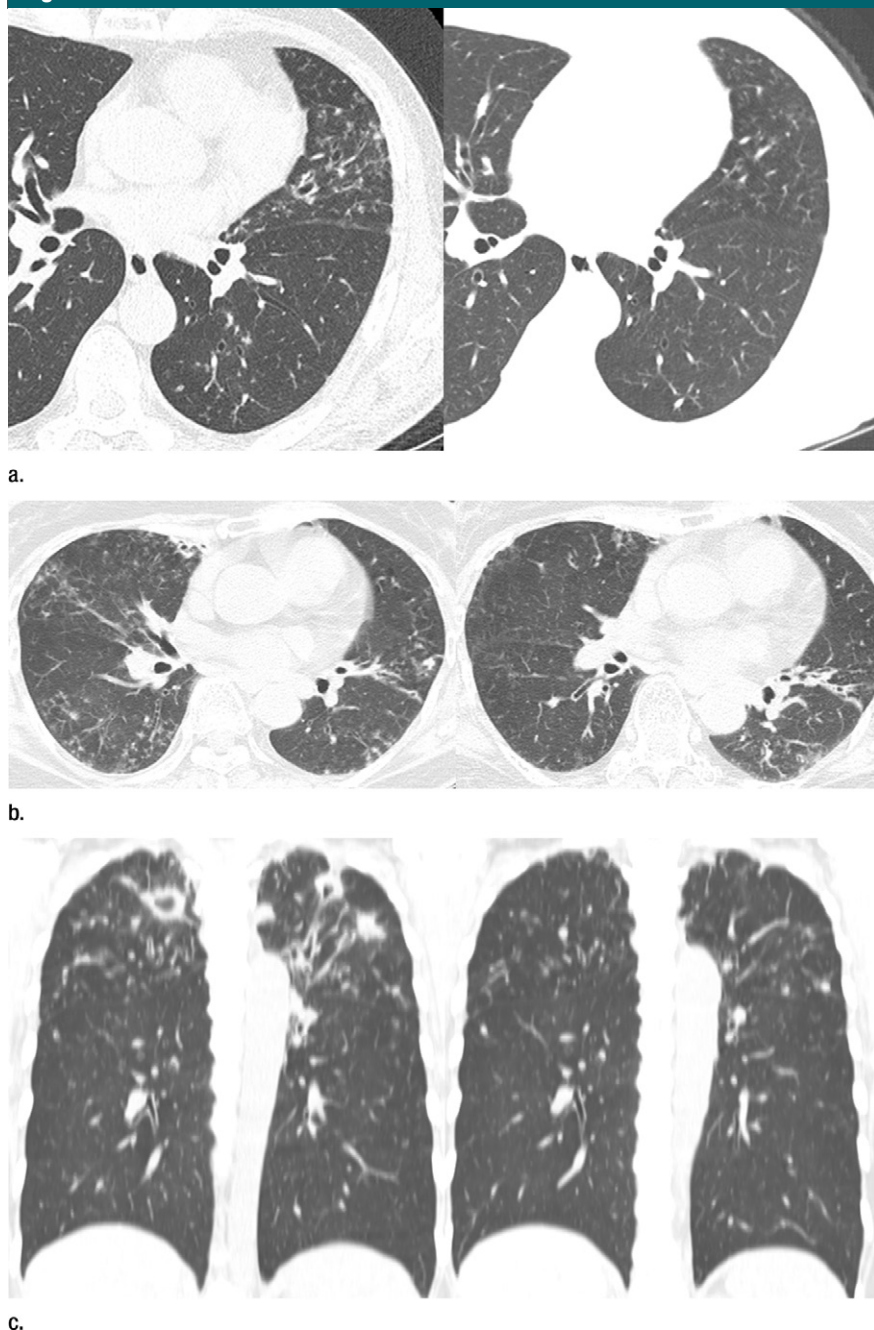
Serial CT scans of *M massiliense* diseases at time points A (left) and C (right). (a) Scans in 63-year-old man show interval improvement of wall thickening of dilated bronchi (severity) in the lingular division of left upper lobe. There was no change in the number (extent) of involved lobes. Total (severity, extent, and mucus plugging) scores for bronchiectasis were 5 (score of 2, 2, and 1, respectively) for time point A and 3 (score of 1, 2, and 0, respectively) for time point C. (b) Scans in 72-year-old woman. Note associated bronchiectasis. Total (severity and extent) scores for cellular bronchiolitis were 5 (score of 3 and 2, respectively) for time point A and 2 (score of 1 and 1, respectively) for time point C. Interval improvement in severity and extent (from seven to four segments involved, not shown here) is overt in both lungs. (c) Scans in 48-year-old woman. Total scores (severity, wall thickness, and extent) for cavitory lesions were 7 (score of 2, 2, and 3, respectively) for time point A and 4 (scores of 1, 2, and 1, respectively) for time point C. Cavities showed obliteration and decreased number of segmental involvement (not shown here).
